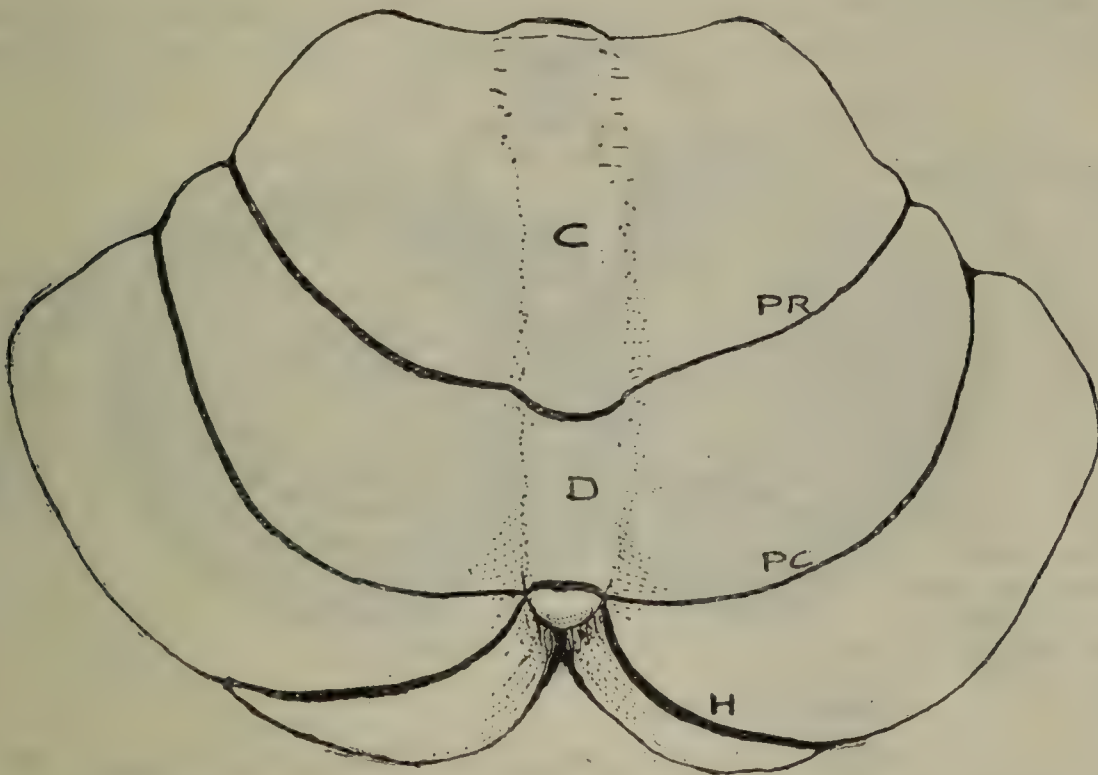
UPPER ASPECT OF CEREBELLUM, WITH MAIN SUBDIVISIONS.
